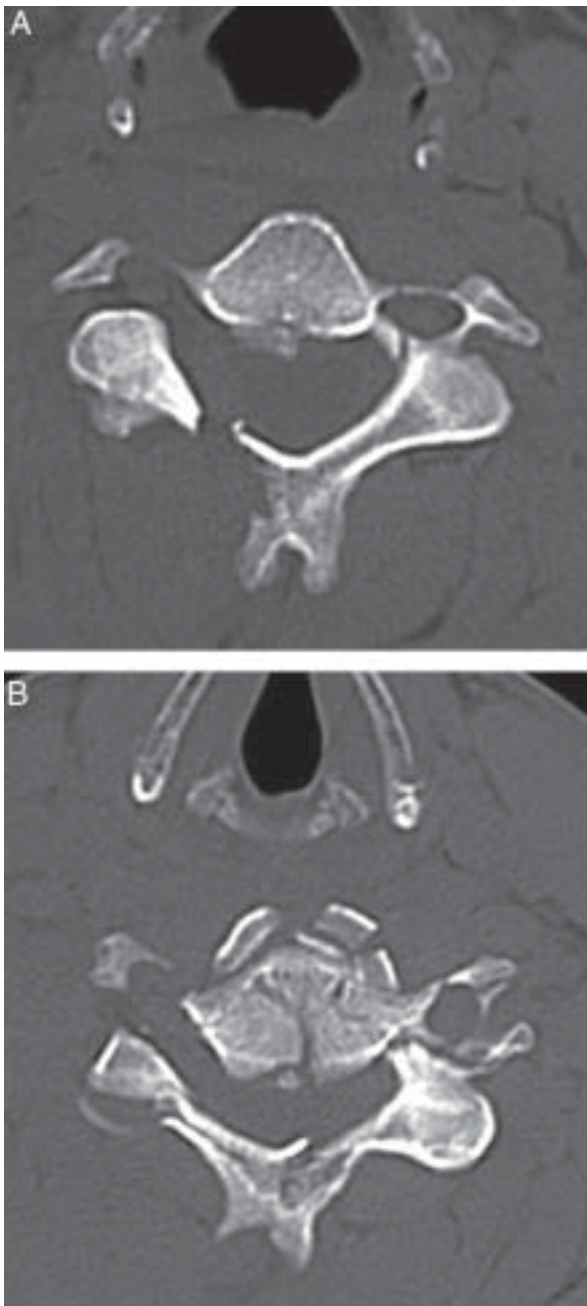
Computed tomography at admission revealed the fractured 4th (A) and 5th (B) cervical vertebra.
